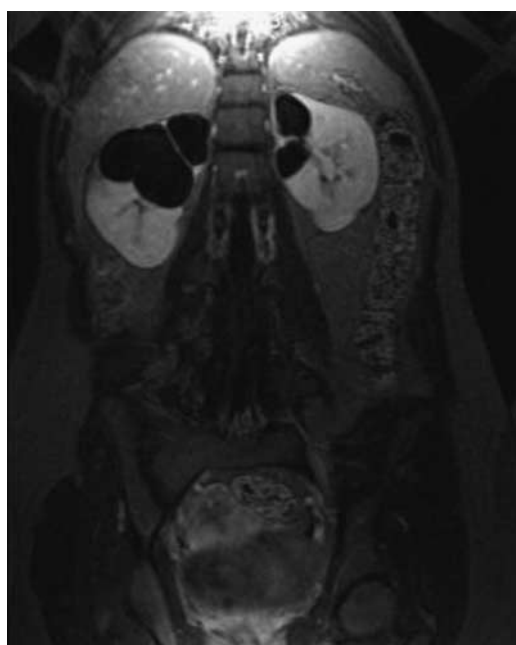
Standard magnetic resonance imaging.
